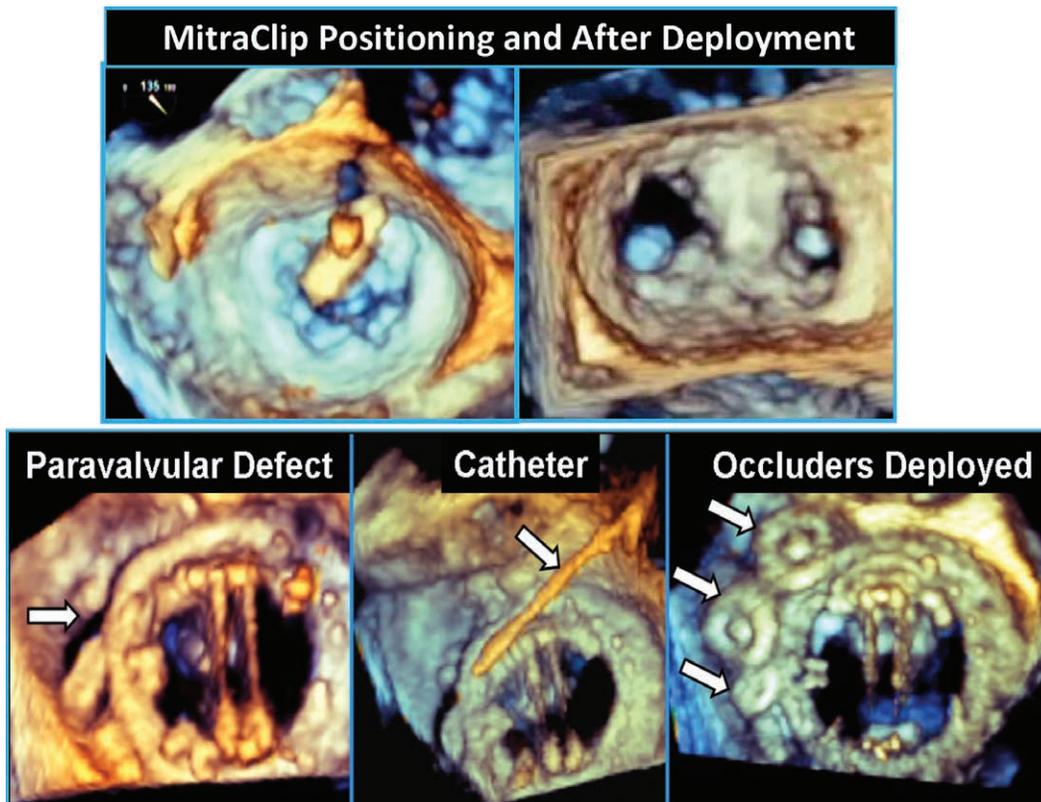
Interventional imaging in the catheterization laboratory. Upper panels: positioning of a MitraClip for repair of mitral regurgitation with 3-dimensional echo transesophageal guidance and images of the valve after deployment. The lower panels show guidance of occluder devices in a patient with paravalvular prosthetic mitral regurgitation.
